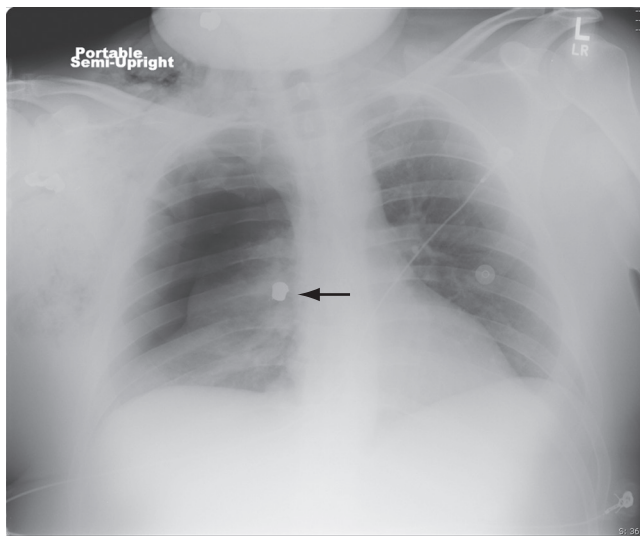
Chest radiograph showing a moderate-sized right pneumothorax. A bullet (arrow) can be seen near the right mediastinum.
